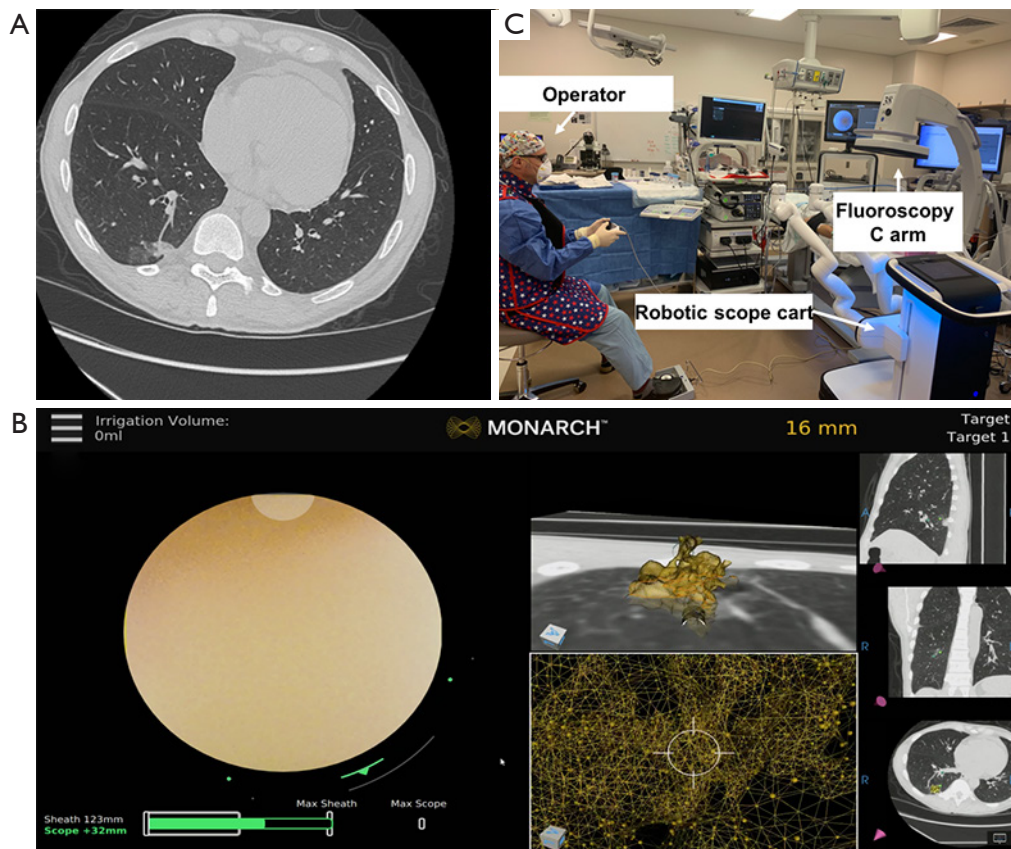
Lung nodule sampling with robotic bronchoscopy. (A) Axial CT scan showing a peripheral mixed ground glass-solid nodule with a vessel leading to it. No “bronchus sign” was noted. (B) The planning was performed based on the “vessel sign”, which led to successful navigation to the target nodule and the scope was parked at 16 mm proximal to the lesion. (C) Operator is seated during the robotic bronchoscopy procedure and could move away from the patient and the X-ray tube.
